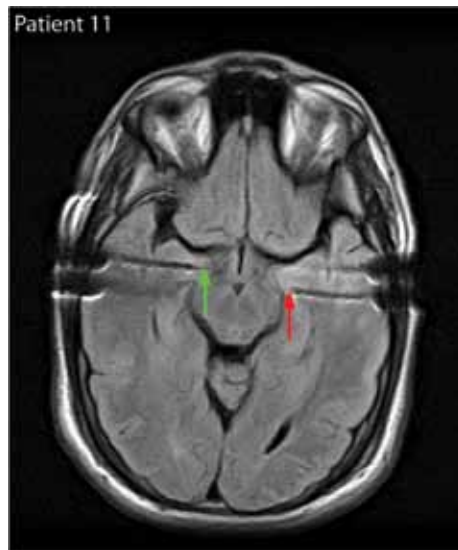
MRI scans of the brain demonstrating the position of the electrodes used to record neuronal activity. The green arrow indicates an electrode placed in the amygdala and the red arrow placement in the hippocampus. Originally published in *Nature* (1).
